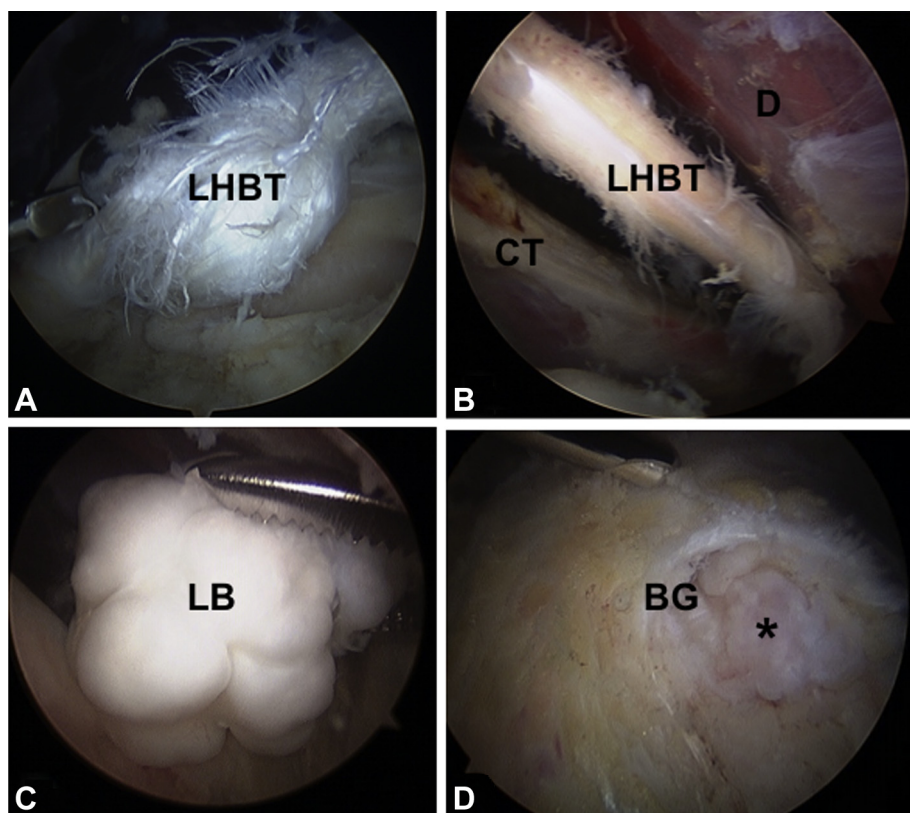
Symptomatic hidden lesions may occur within the bicipital tunnel. Such lesions can include (A) partial tearing of the long head of the biceps tendon (LHBT), (B) scar/adhesion formation, (C) loose body collection, and (D) osteophyte formation (asterisk) along the floor of the bicipital tunnel. (CT, conjoint tendon; D, deltoid; BG, bicipital groove; LB, loose body.)
